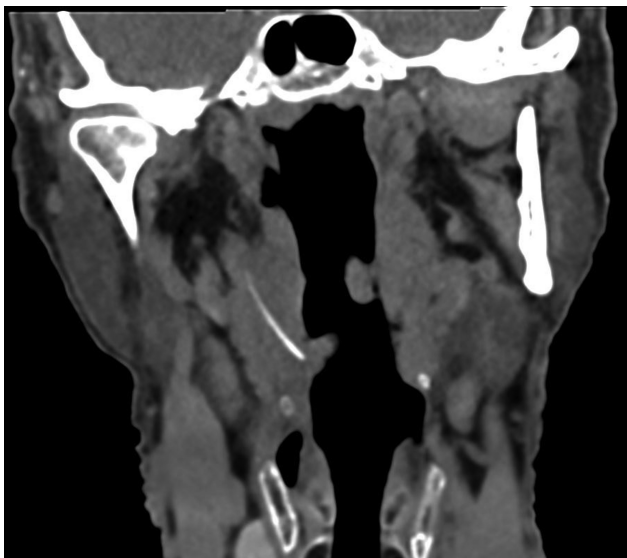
Coronal non-contrast computed tomography image. A thin linear calcification is seen adjacent to the right pharyngoepiglottic fold close to the mucosal surface, traversing the pharyngeal mucosal space and the parapharyngeal space with no significant surrounding swelling or edema.
